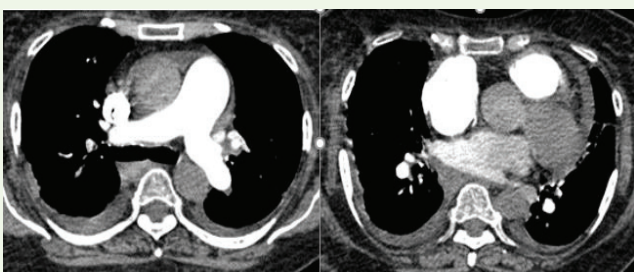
CT pulmonary angiography (CTPA) demonstrates normal opacification of the main, lobar, segmental, and subsegmental pulmonary arteries with no evidence of intraluminal filling defect or thrombus. The total modified Wells score is 3 (≤ 4 ; PE unlikely); however, despite a markedly elevated age-adjusted D-dimer level of 3300 (positive), there is no imaging evidence of pulmonary embolism on CTPA.
